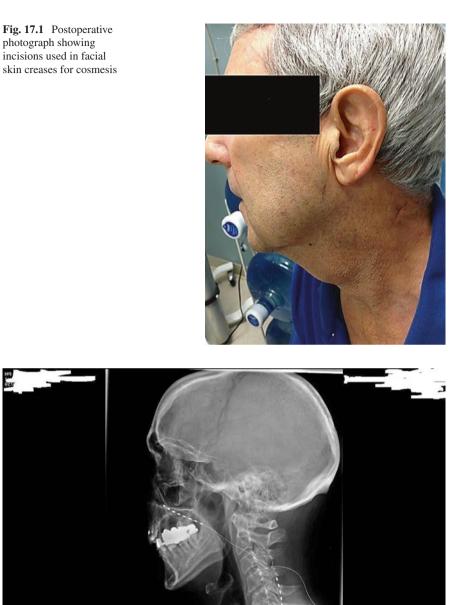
Lateral radiograph revealing permanent lead position with 100% relief
